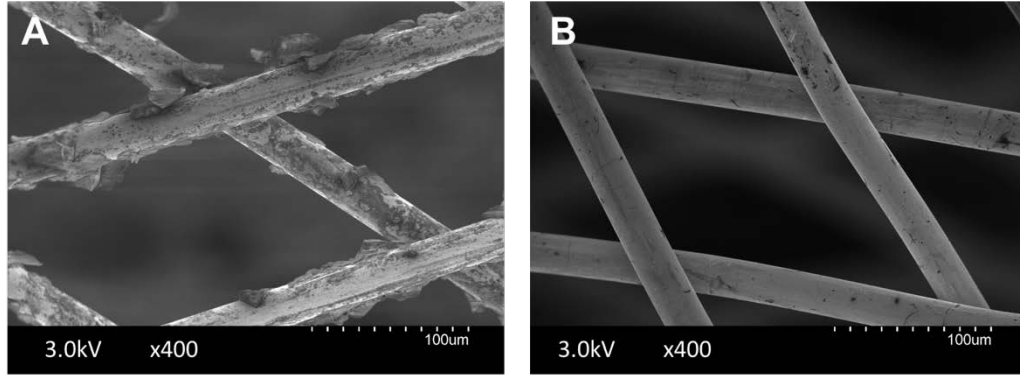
(A) SEM image of commercial flow diverting device #1 prior to ultrasonic cleaning with the established protocol. (B) The same device after ultrasonic cleaning.
